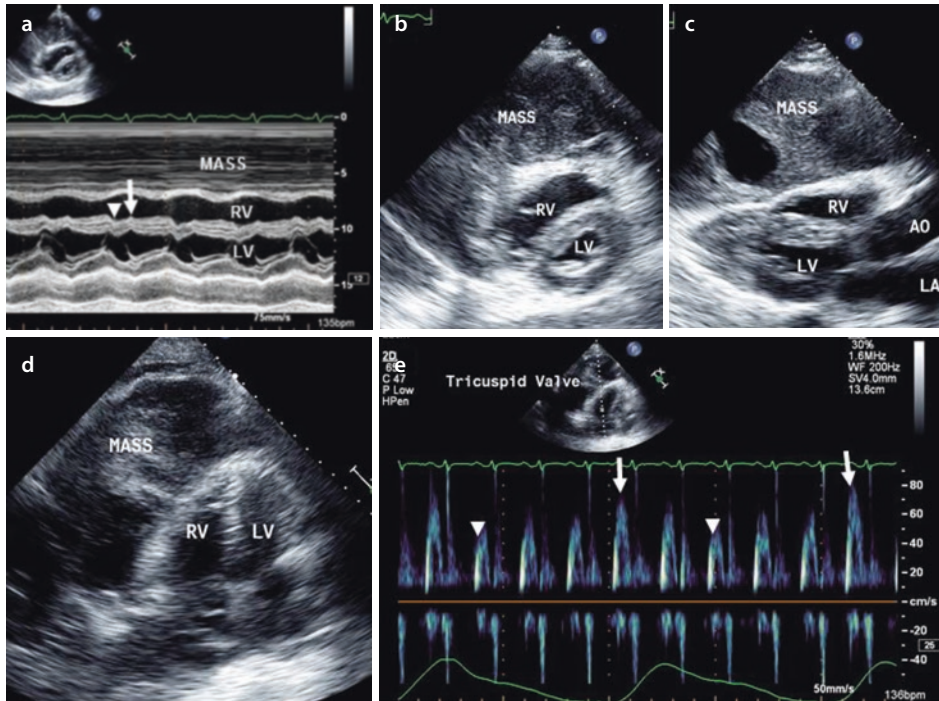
Large mediastinal germ cell tumor causing cardiac tamponade or constriction-like echocardiographic findings. a This two-dimensional (2D) guided parasternal short-axis M-mode echocardiogram demonstrates a large retrosternal germ cell tumor (*mass*) extending to the pericardium and compressing the entire heart, predominantly the right ventricle (RV). Limited systolic and diastolic excursion of both ventricles with small cavities and the consequent abnormal double dip (posterior and then anterior) septal motion (*arrowhead* and *arrow*). b, c, d These 2D parasternal short- b and long-axis c views and apical four-chamber view d define better the large soft tissue echoreflectant mass with cystic transformation extending to the anterolateral pericardium and compressing the entire heart with consequent compromised filling leading to small ventricles. e Pulse wave Doppler echocardiography of the tricuspid inflow demonstrates a significant increase (>30%) from expiration (*arrowheads*) to inspiration (*arrows*) of early inflow velocities indicative of hemodynamically significant cardiac compression. Adapted with permission from Roldan CA. *The Ultimate Echo Guide*. Lippincott Williams & Wilkins, Philadelphia 2012
